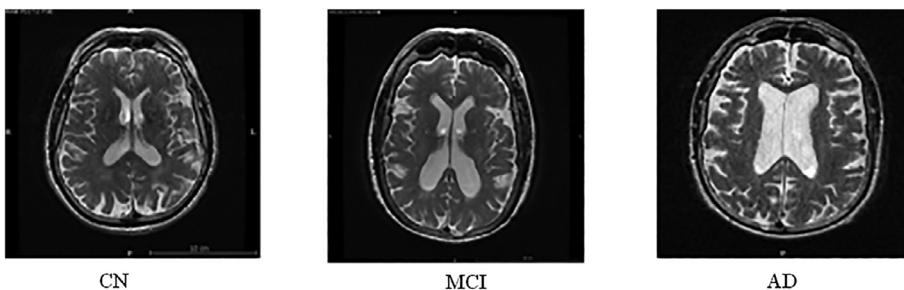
Atrophy changes in the MRI at different stages
